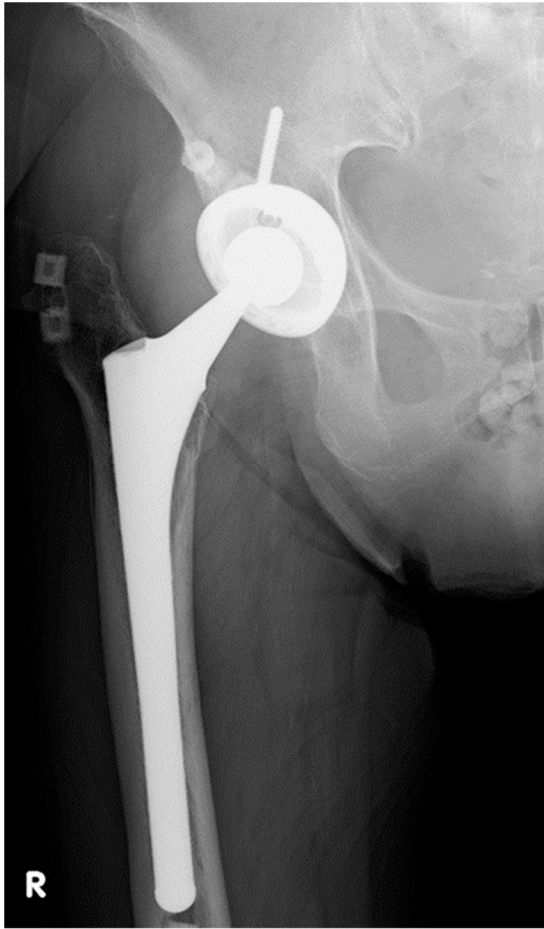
Radiographs of the right hip of a 69-year-old woman.
